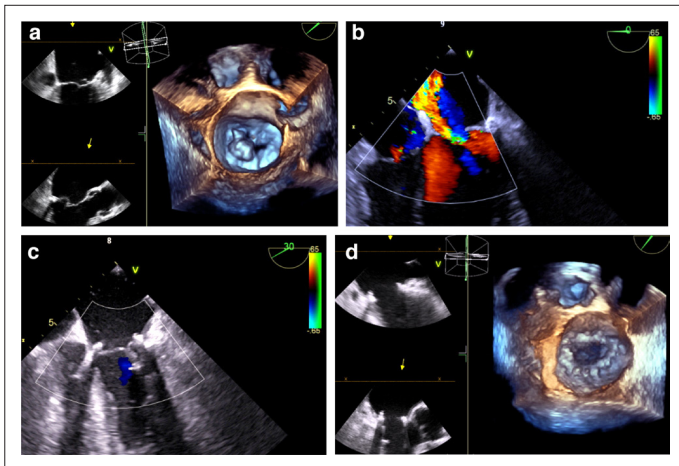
Preoperative transesophageal echocardiography of the mitral valve before surgical repair in 3D (a) and in 2D with Doppler (b) showing prolapse of the posterior mitral leaflet resulting in mitral regurgitation and an eccentric jet. Postoperative transesophageal echocardiography of the repaired mitral valve after surgery in 2D with Doppler (c) and in 3D (d) showing no residual mitral regurgitation. 2D, 2-dimensional; 3D, 3-dimensional.
